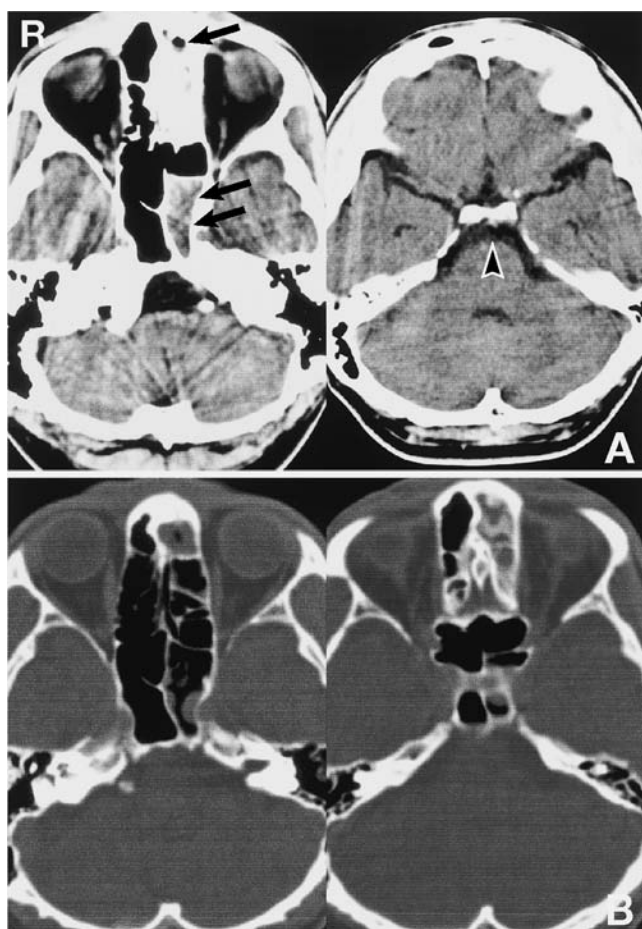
A: Computed tomography scans on admission showing opacification of both the left sphenoid sinus (double arrow) and part of the frontal sinus (arrow). No intracranial abnormality is demonstrated especially around the basilar artery (arrowhead). B: Computed tomography scans showing no bony defect of the clivus.
